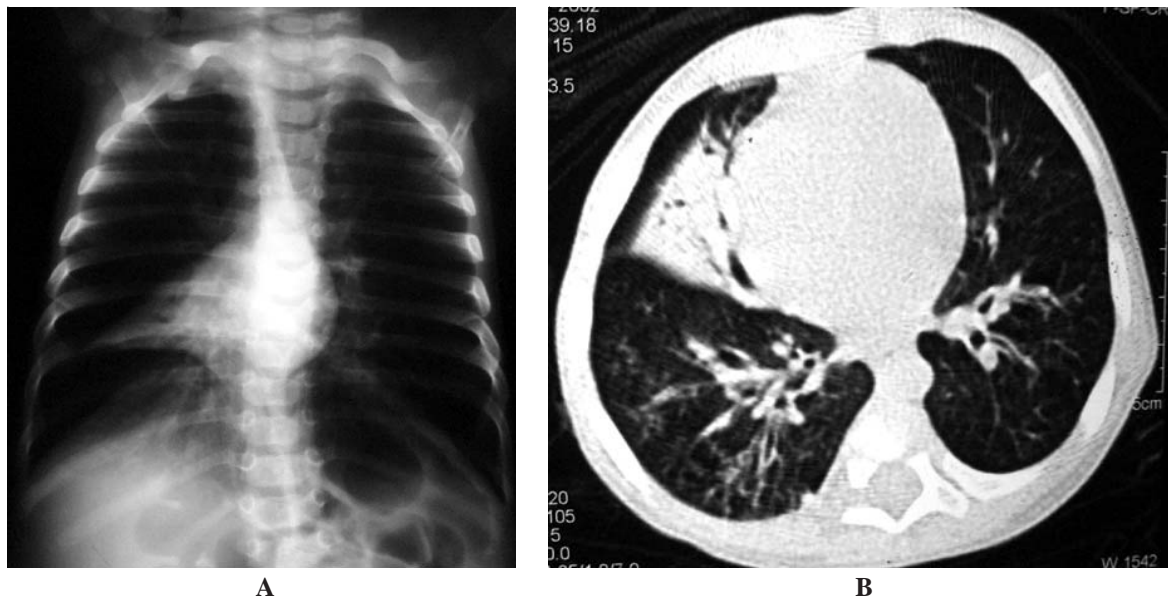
The chest X-ray and computerized tomography of the chest of Case No. 1
